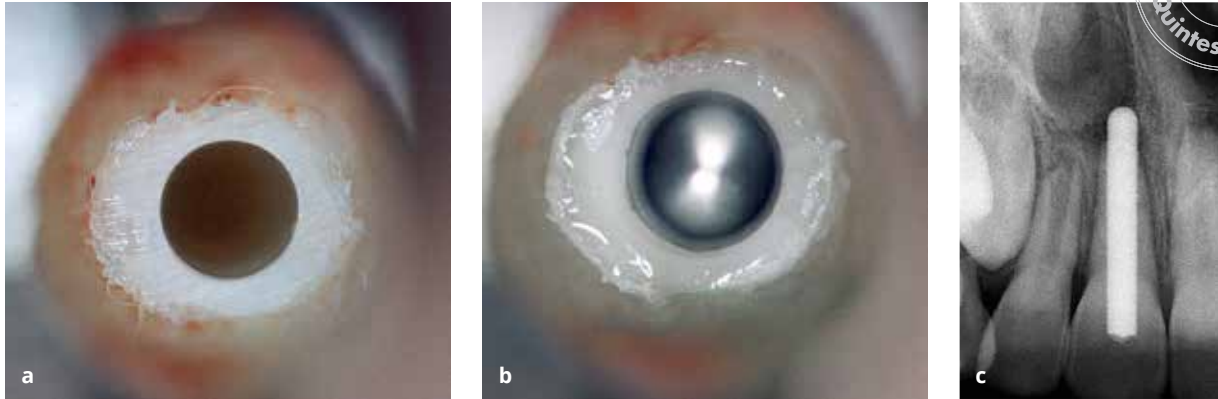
Retrograde post insertion. (a) Situation after wide-lumen rotary preparation. (b) Sealer fixation of a smooth cylindrical titanium post. (c) Resulting radiograph.
